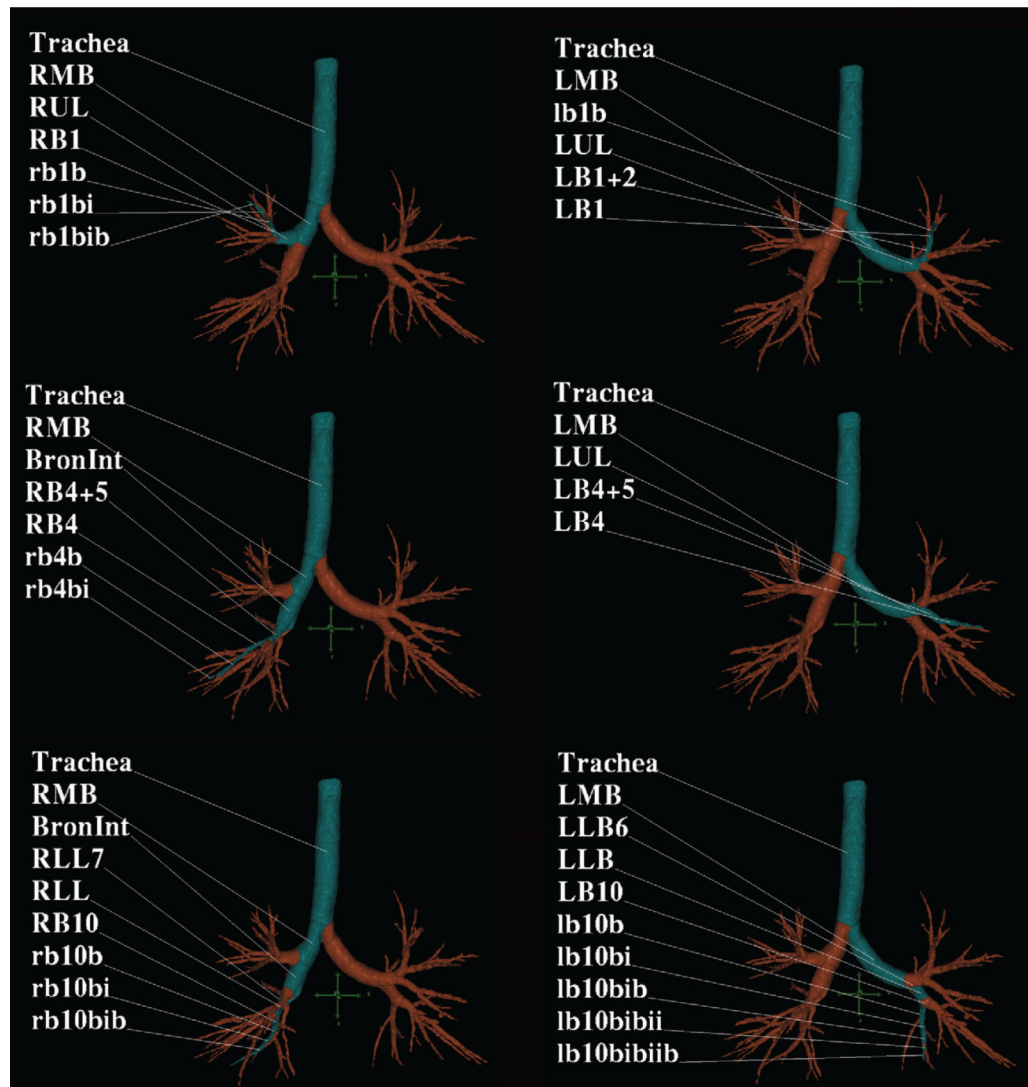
Quantitative CT of airways in asthma
